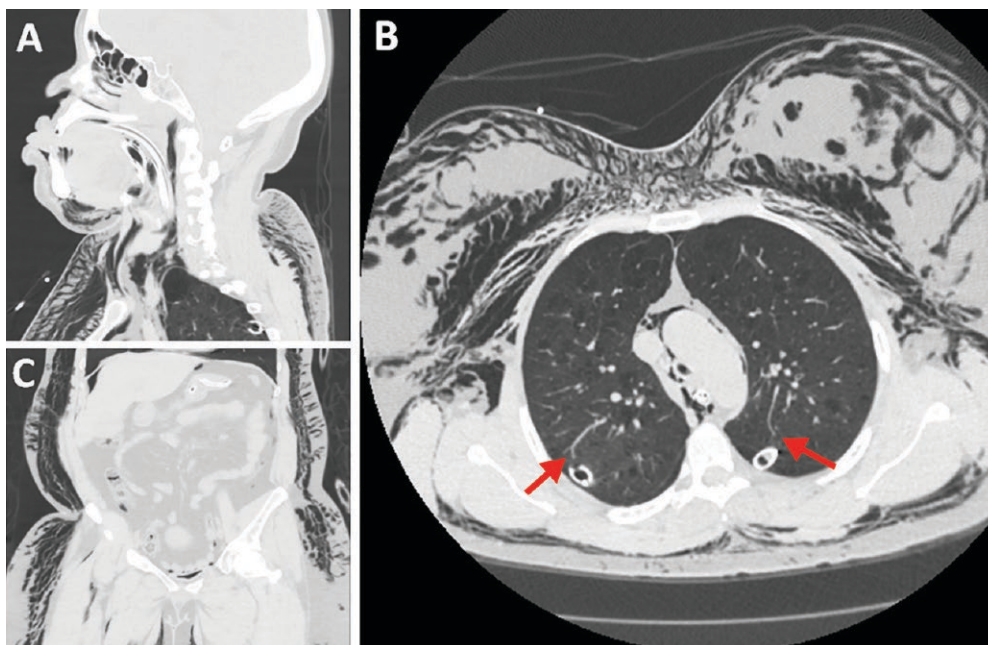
Computed tomographic (CT) imaging demonstrating extensive subcutaneous emphysema (A-C), apical bleb (A), emphysematous changes in the lungs (B) and bilateral chest tubes (B; arrows).
